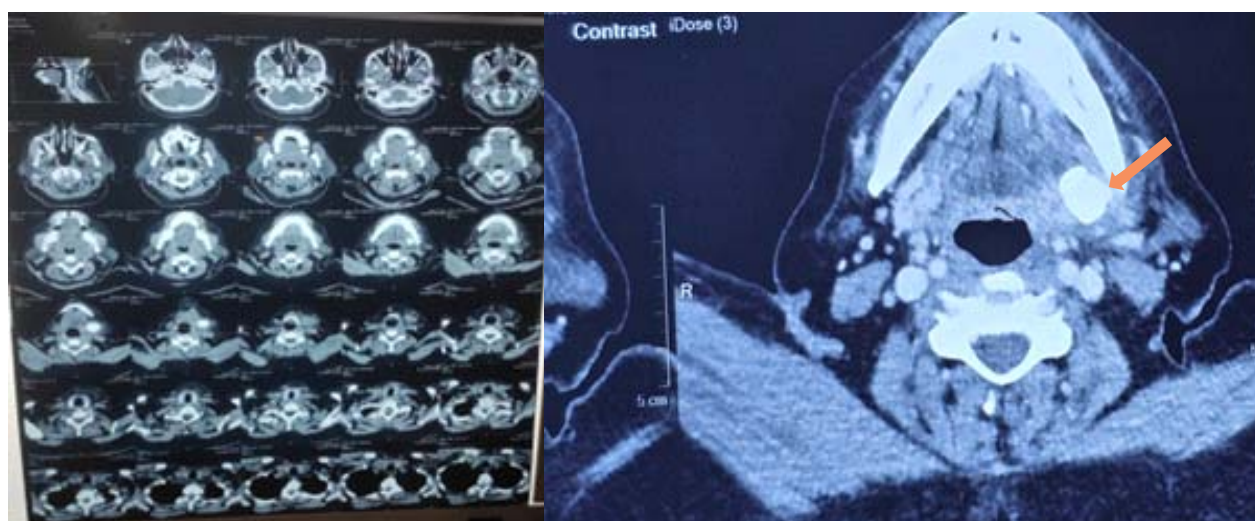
Contrast-enhanced CT showing submandibular calculus.
